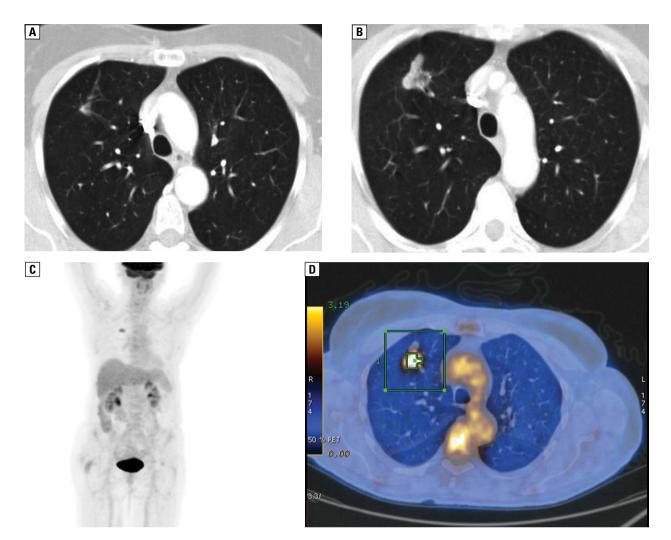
Inflammatory pseudotumour. A — pulmonary window, axial image of CT scan shows nodule localised in the right upper lobe; B — after 6 months, the nodule in the right upper lobe enlarged; C, D — increased 18F-FDG uptake is seen on PET-CT, suggesting neoplastic origin. Lesion was resected and pathology revealed an inflammatory pseudotumour
